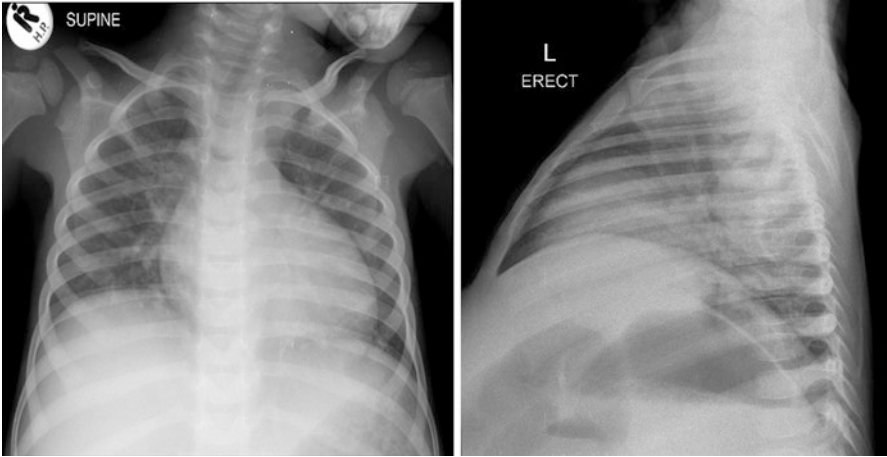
Chest X-ray (normal)
